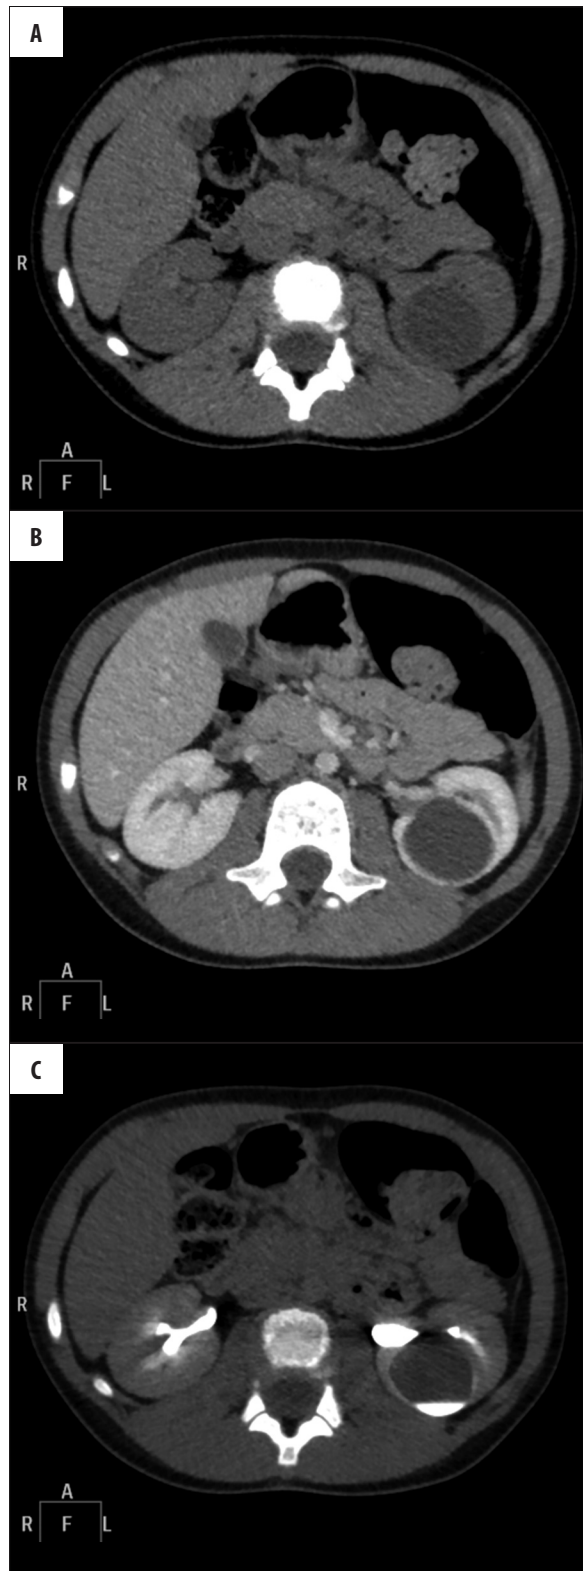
Multiphase CT urography (phases: unenhanced, parenchymal and delayed 15 min. after IV contrast injection) (A–C). Examination revealed contrast filling of the cyst – delayed phase (C) demonstrates level of the contrast and increased enhancement of fluid within the cyst, confirming communication between the renal cyst and the collecting system.
